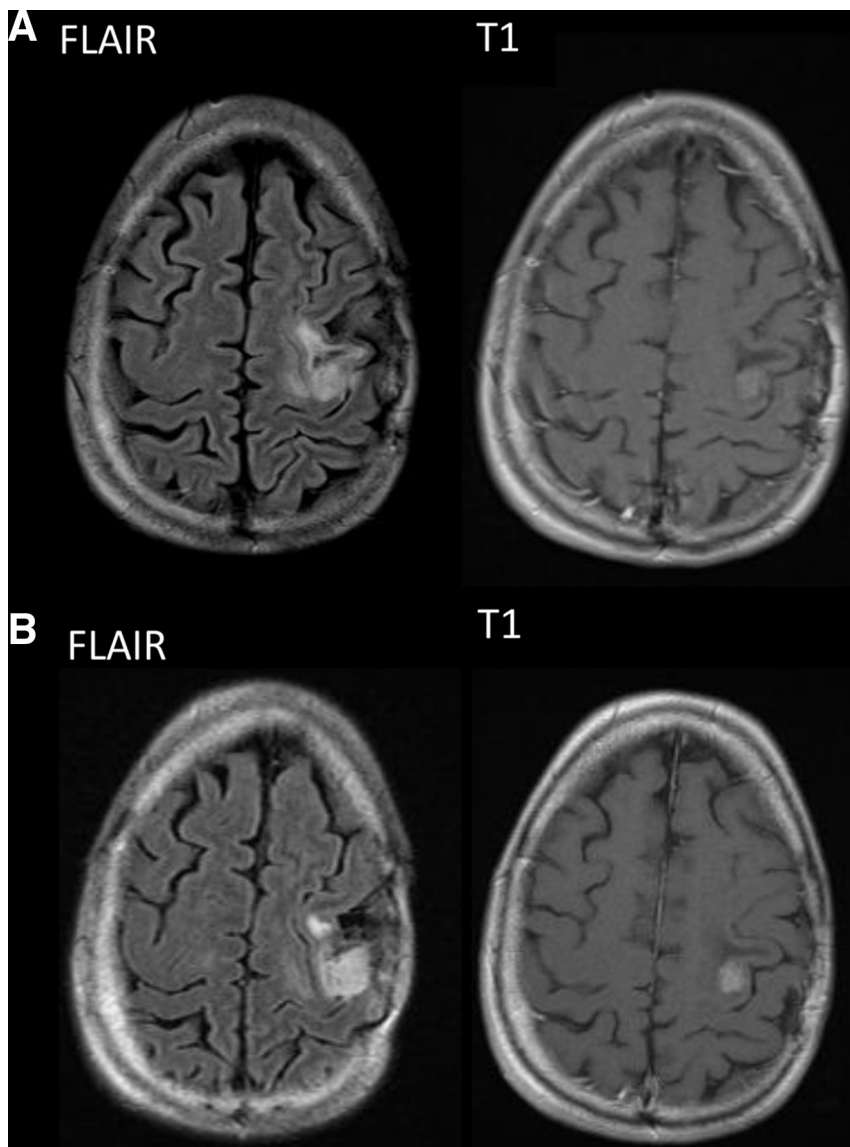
FLAIR and T1 with contrast MRI at onset (A) and at 1-month follow-up (B) showing increased enhancement in the left parietal surgical cavity raising the question of tumor progression. Abbreviations: FLAIR, fluid-attenuated inversion recovery; MRI, magnetic resonance imaging.
